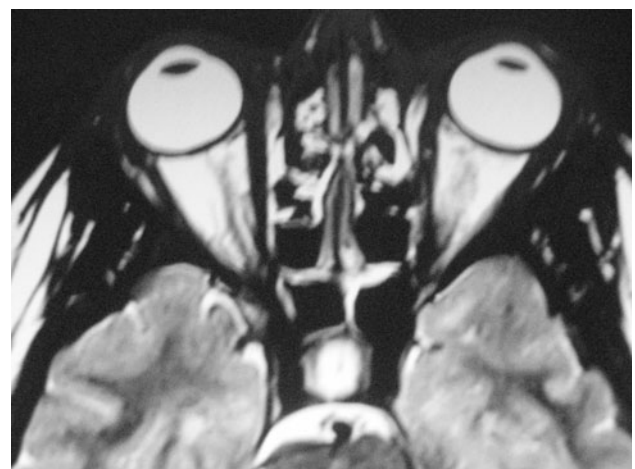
Cranial MRI pointing papillitis
